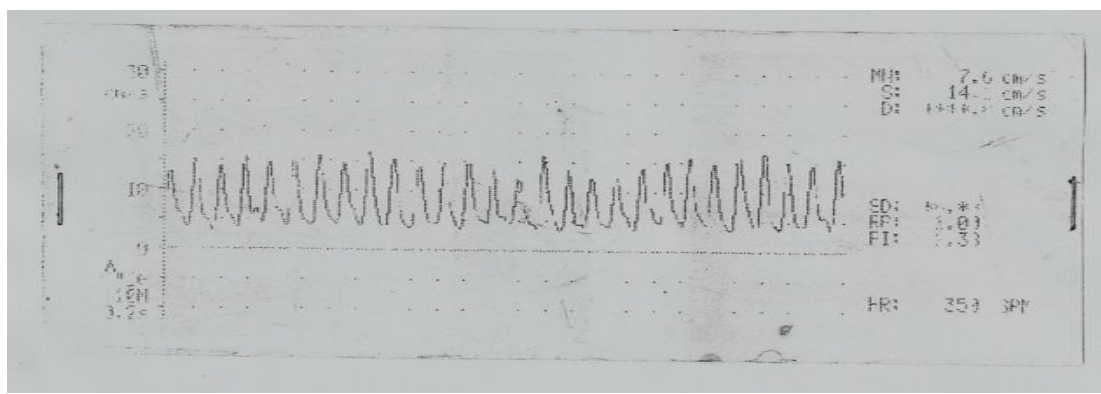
Doppler ultrasound record of testicular blood flow in sildenafil treated group
